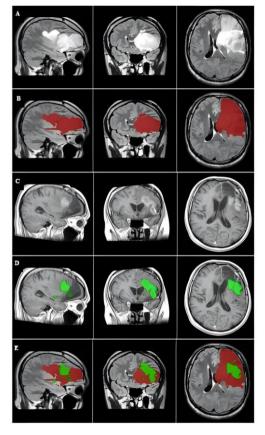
Case 1. Tumor Recurrence and FLAIR Overlap. All images are in MNI152 1mm space. -High sensitivity vs low specificity most regions in primary tumor mask are true cancerous tissue -Supports FLAIR imaging as effective for assessing tumor proliferation -FLAIR hyperintensity may overestimate tumor boundaries -Overestimation can result from factors like edema -Potential impact on diagnosis and treatment
